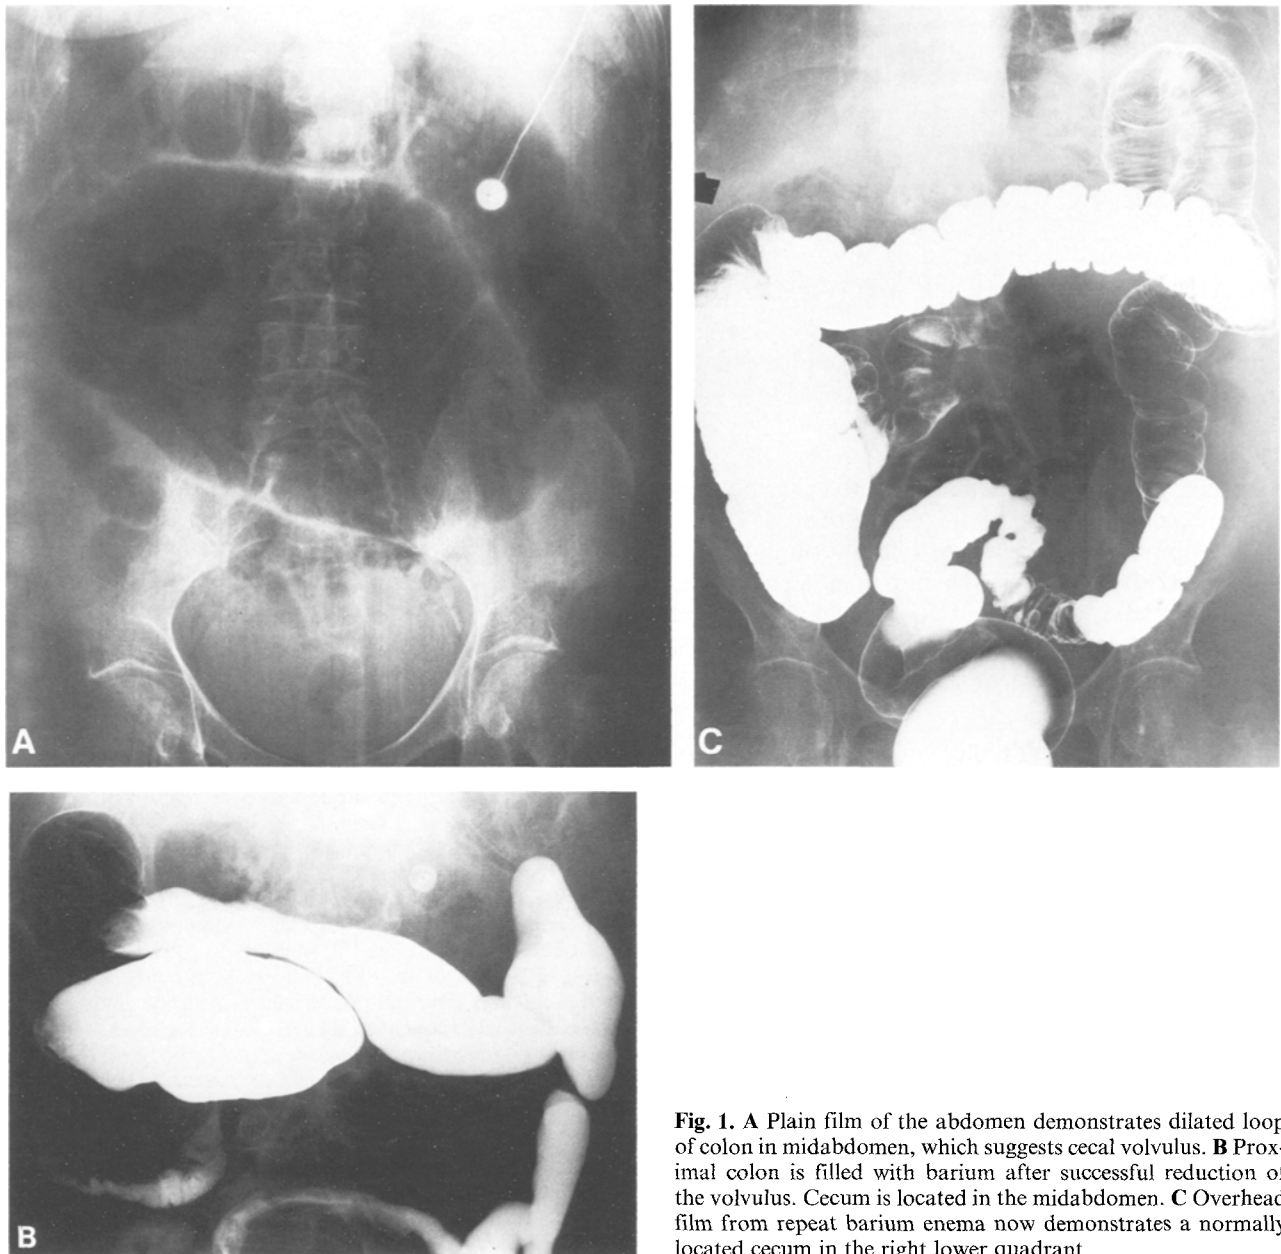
A Plain film of the abdomen demonstrates dilated loop of colon in midabdomen, which suggests cecal volvulus. B Proximal colon is filled with barium after successful reduction of the volvulus. Cecum is located in the midabdomen. C Overhead film from repeat barium enema now demonstrates a normally located cecum in the right lower quadrant
